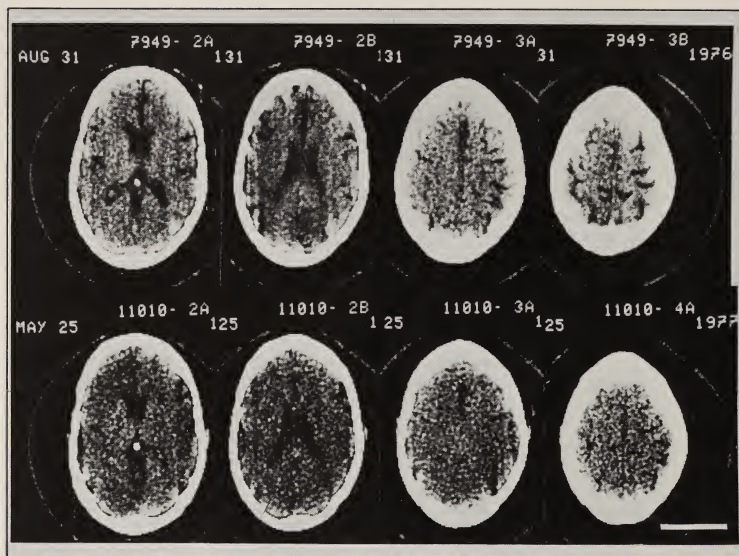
Reversible cerebral atrophy in a recently abstinent 35-year-old male alcoholic who showed a remarkable and steady improvement over 40 weeks of maintained abstinence. Psychological testing, at four and 40 weeks showed a Performance IQ increase of 34 points. Ventricles are dark areas in the central portion of pictures on the left. The typical walnut-shell appearance of cortical and sulcal atrophy is seen in pictures on the right. The top row shows four contiguous CT scan cuts taken four weeks after the patient's last drink and demonstrates enlarged ventricles and numerous and enlarged cortical sulci. The bottom four CT scan cuts taken eight months later show a reduction in ventricular size with a more marked reduction in size and number of visible cortical sulci. Variation in the photographic quality of the two scans cannot account for the observed changes. In a normal patient of the same age, ventricles are much smaller and sulci are usually not visible on CT scans. The calibration line represents 20 mm on standard Polaroid photographs and 7.8 cm in actual tissue. Reproduced with permission from Science (Carlen et al., 1978).*
